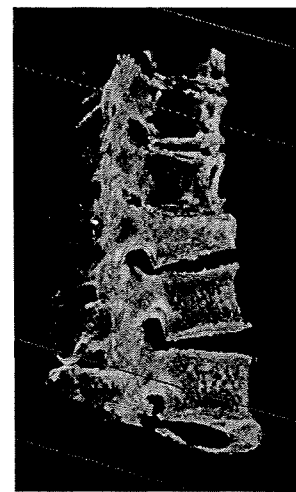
Three-dimensional radiograph after injection of polymethylmethacrylate (lateral view).
